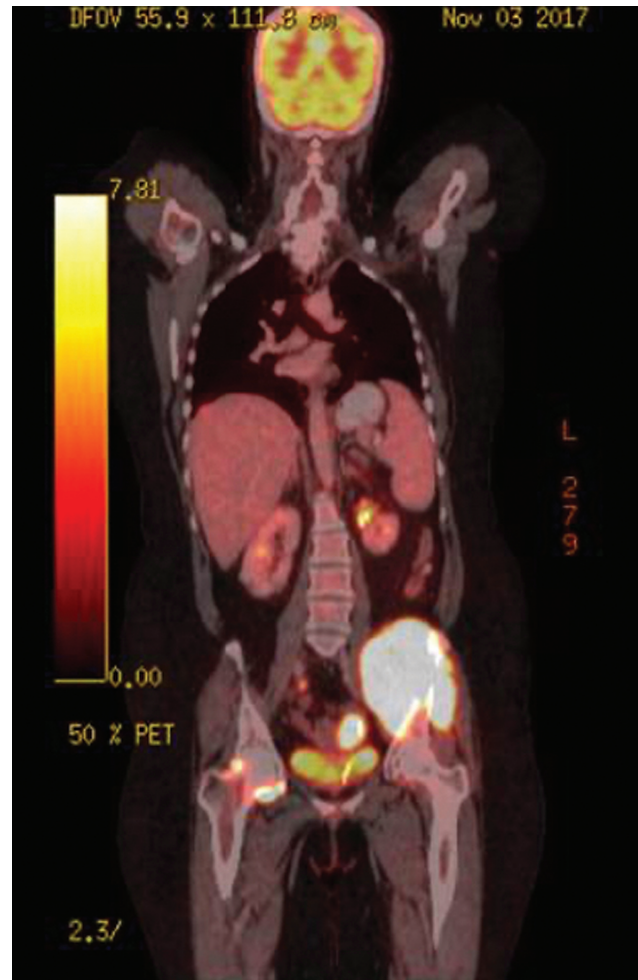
Positron emission tomography-computed tomography demonstrating a hypermetabolic lesion at the left iliac blade. Multiple metabolically active deposits are seen in the lungs, abdomen, and hip joints also.
